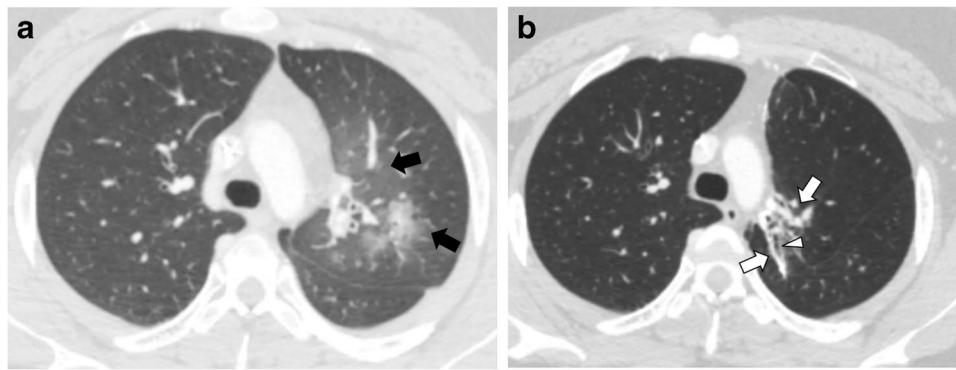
Radiation pneumonitis in a 17-year-old boy with Ewing-like sarcoma of the left lung post radiation and chemotherapy. a Axial CT image in the acute phase shows areas of ground-glass opacity in the radiation field (*arrows*). b One year later, axial CT shows fibrosis as
